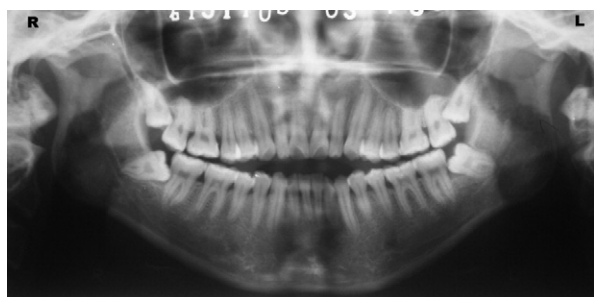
A sample of a representative 21-year-old woman is shown. Panoramic radiogram showed shortening of the bilateral condyles with anterior open bite.
